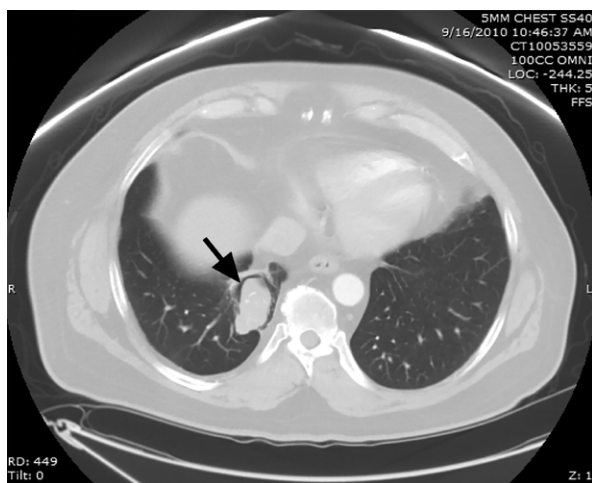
Patient 1. Computed tomogram shows an intralobar pulmonary sequestrum in the right lower lobe (arrow).
